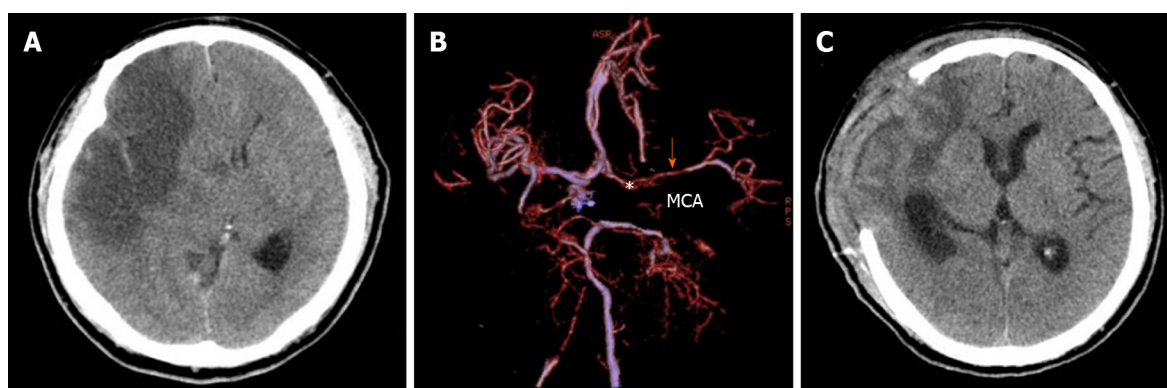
Imaging of case 6. A: Computed tomography revealed right frontotemporal infarction (ellipse) with a mass effect on the lateral ventricle and a midline shift; B: Computed tomography angiography revealed right internal carotid artery occlusion (asterisk) and a thin middle cerebral artery (arrow); C: Computed tomography revealed the decompression craniectomy with expansion of the infarcted brain parenchyma. MCA: Middle cerebral artery.
